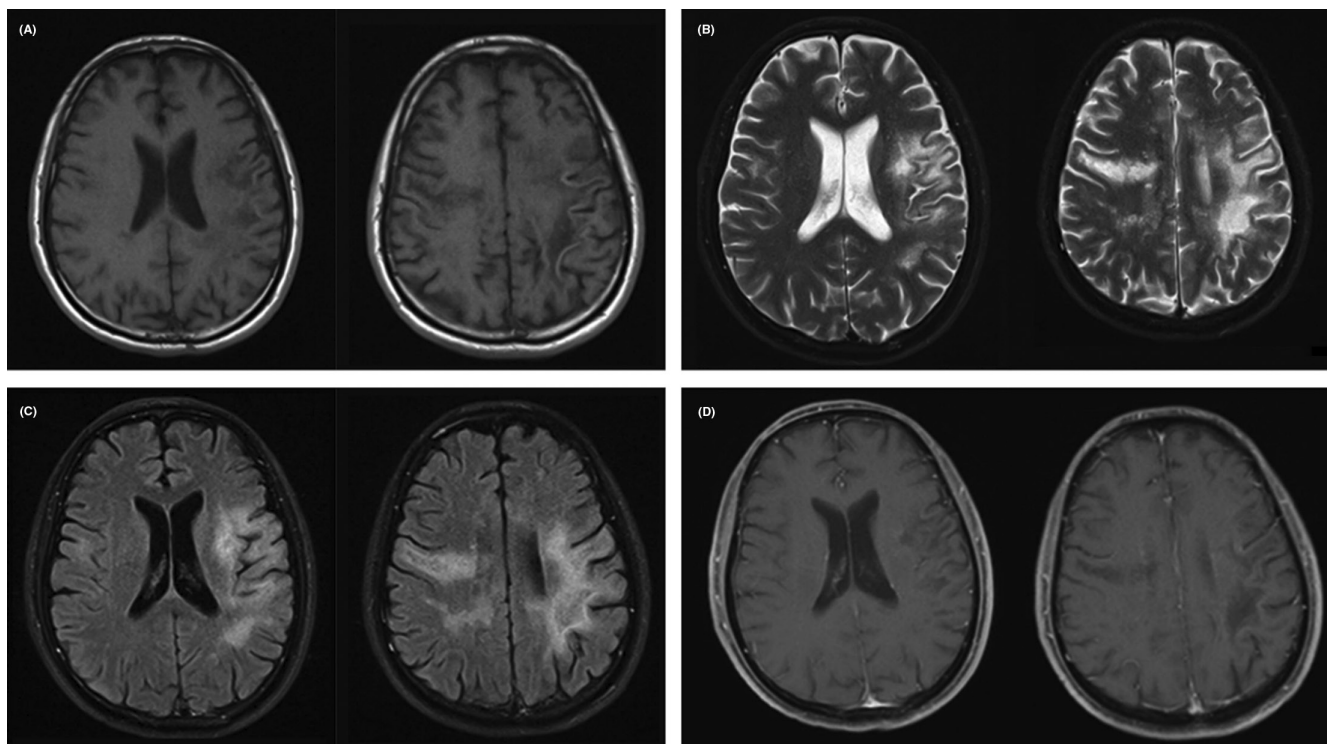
Magnetic resonance imaging results. T1-weighted images (A) showed multiple asymmetric patchy signal shadows on the subcortical bilateral frontal, temporal, and parietal lobes. These lesions were hyperintense on T2-weighted images (B) and T2 fluid-attenuated inversion recovery (FLAIR) images (C). No significant enhancement and mass effect was seen (D).
